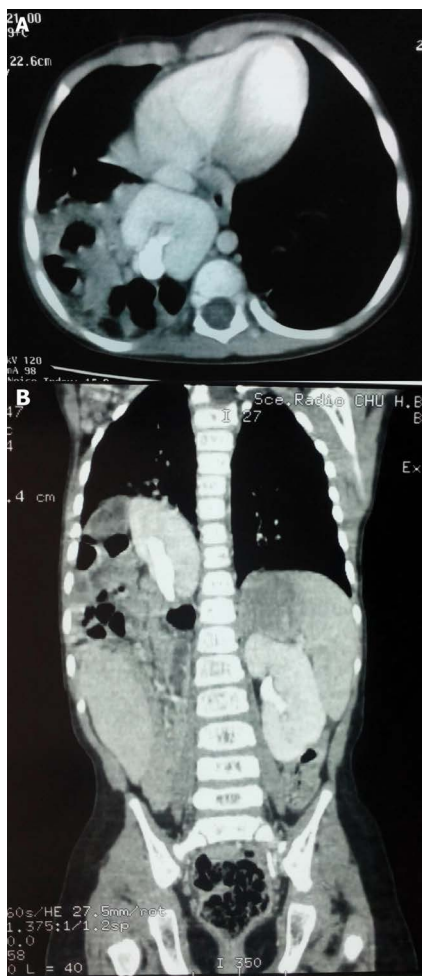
(A) Contrast-enhanced axial computed tomography (CT) scan demonstrating the presence of an ectopic reniform structure with bowel loops in the intrathoracic location on the right side. (B) Contrast-enhanced coronal CT scan demonstrating the presence of an ectopic reniform structure with bowel loops in the intrathoracic location on the right side.
